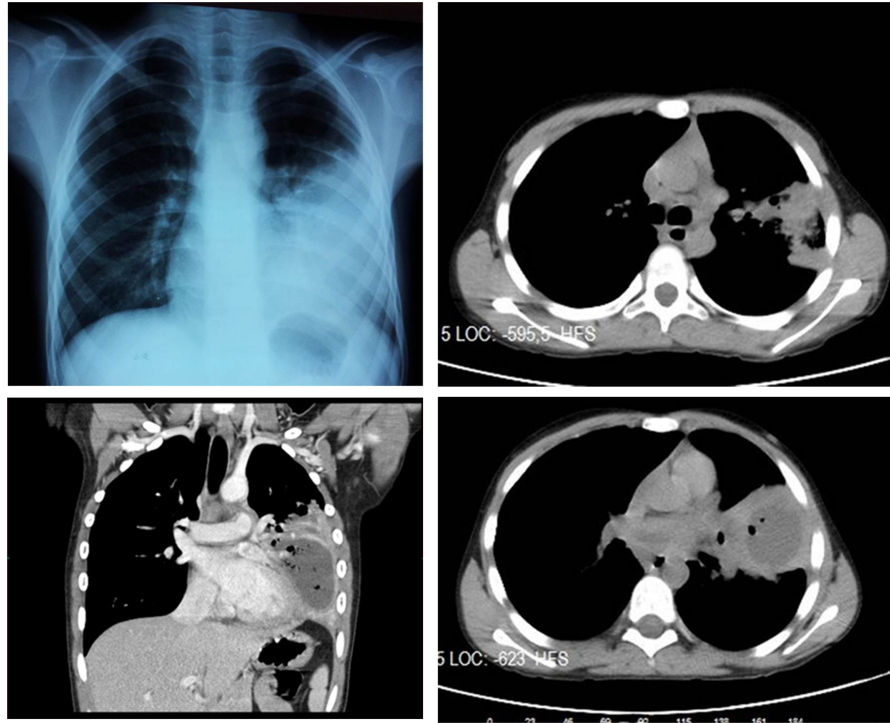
Chest radiography and computed tomography demonstrating cavitary pneumonia and pulmonary abscess.
